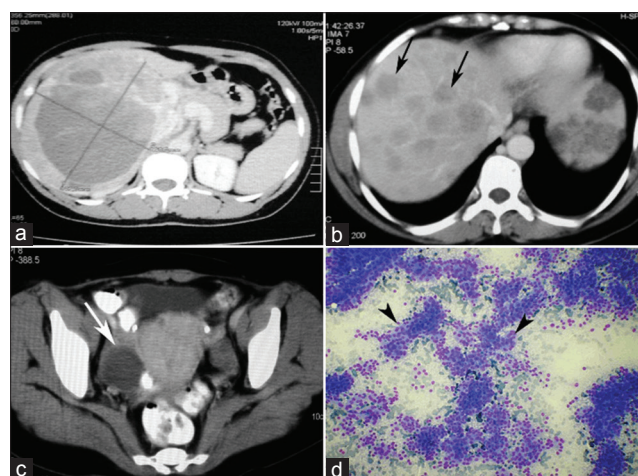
Axial views of computed tomography scan showing large right renal mass abutting and displacing inferior vena cava, (a) multiple liver lesions showing early washout (black arrows) (b) and uterus and right adenexal mass (3 cm × 4 cm) (white arrow). (c) Photograph of fine needle aspiration cytology smear (Giemsa ×200) from liver showing clusters of malignant cells with predominant perivascular arrangements (arrow heads) (d)
